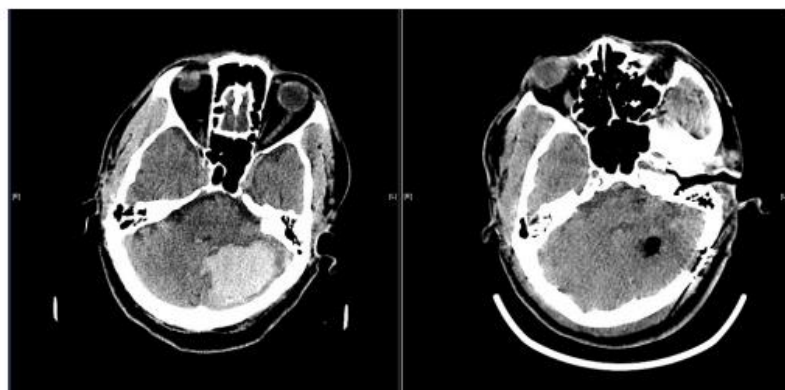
Pre and Post Operative CT Scan
